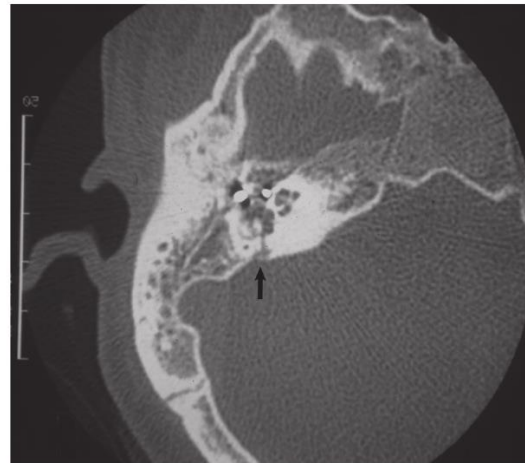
Axial-cut high-resolution computed tomography scan demonstrating a transverse-oriented fracture that resulted from a gunshot injury and disrupted the otic capsule. The arrow points to the fracture line.
